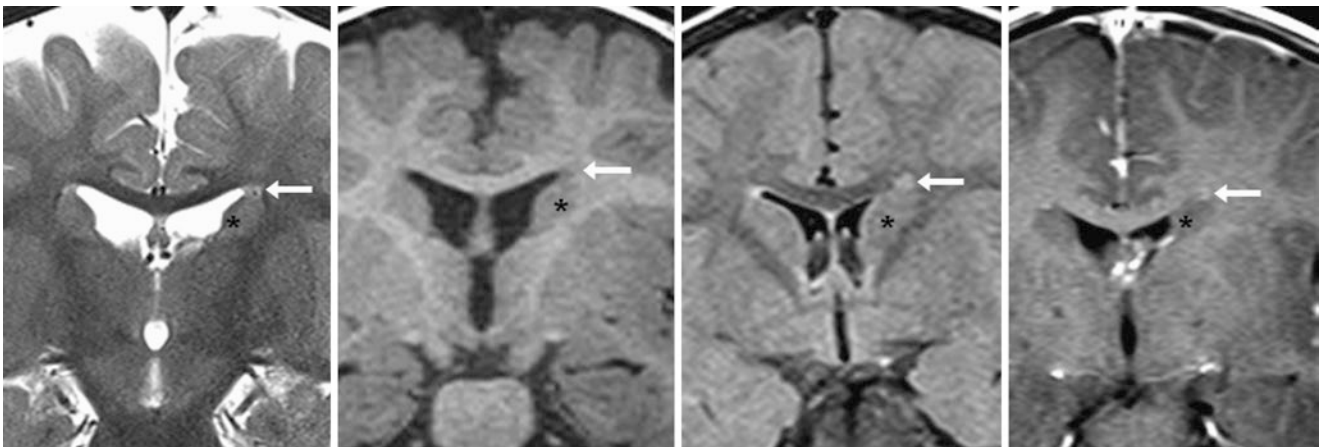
A 9 month old with a left-sided PEP (*arrows*) on coronal T2WI MRI (*left*), not well seen on T1WI (*left middle*). One year later, FLAIR images (*right middle*) show that the PEP appears asymmetric and could be mistaken for a focus of demyelination, which this patient
